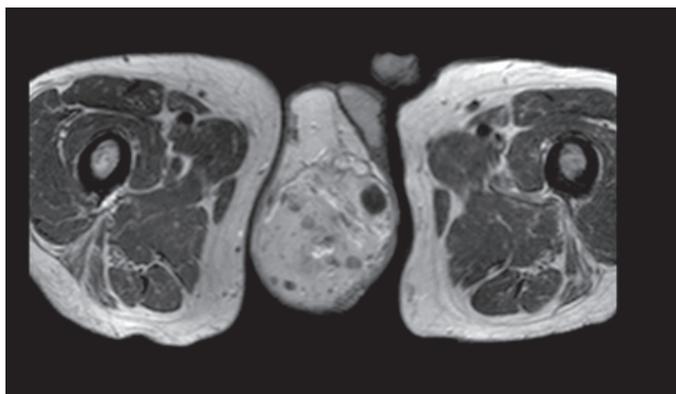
T2 magnetic resonance imaging scan axial view showing a dominant right testicle with multiple cystic lesions.
